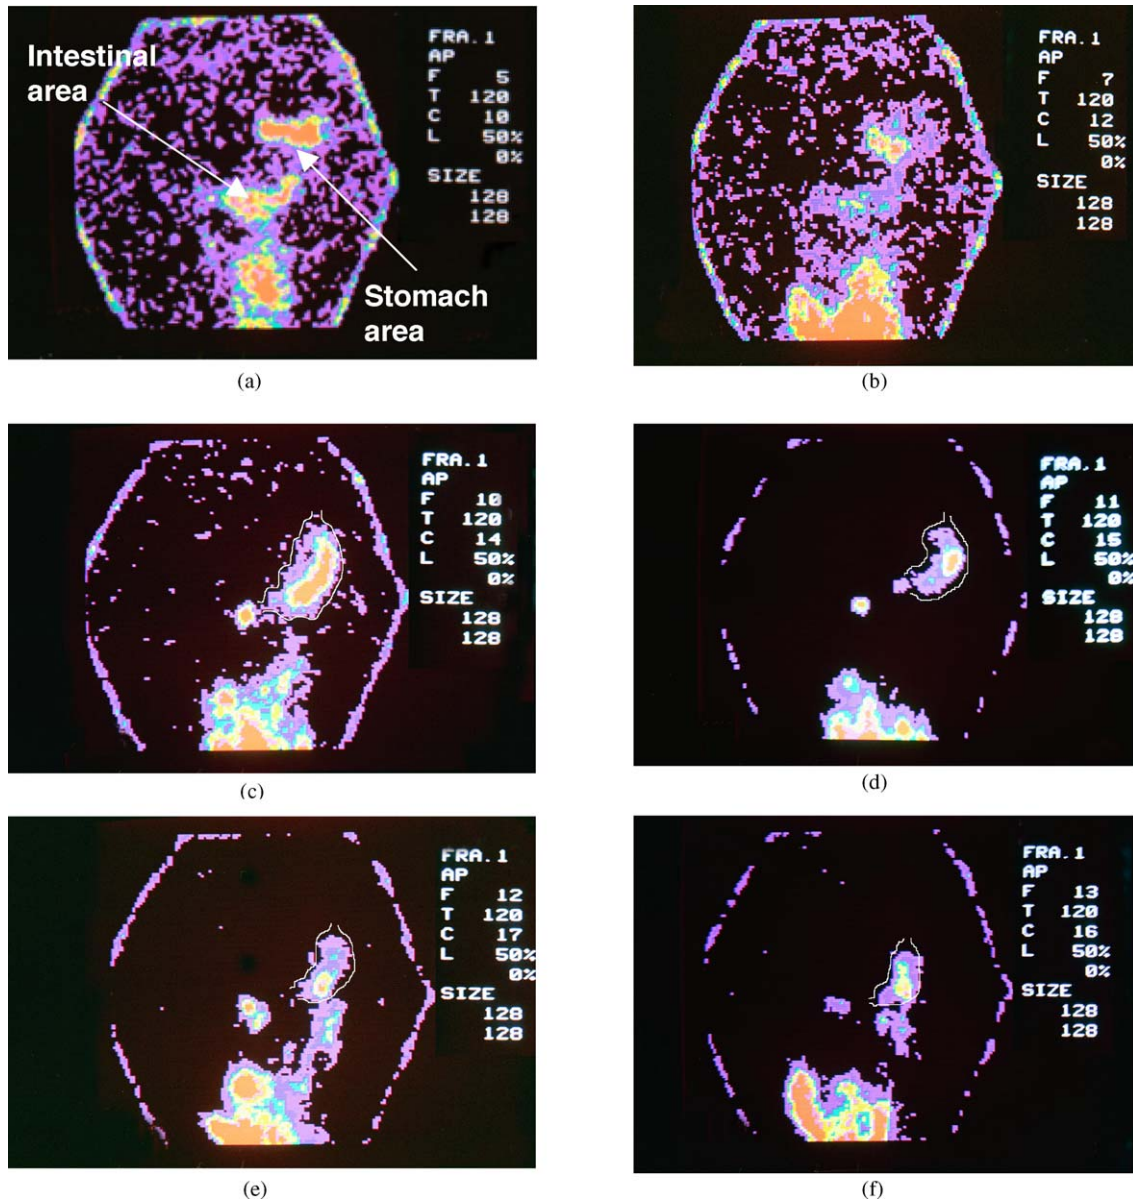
Gamma scintigraphic images showing the movement of calcium alginate beads for volunteer 1 at selected time-points when the beads were administered with 100 ml of water: (a)  $t = 30$  min; (b)  $t = 50$  min; (c)  $t = 80$  min; (d)  $t = 90$  min; (e)  $t = 100$  min; (f)  $t = 110$  min.
